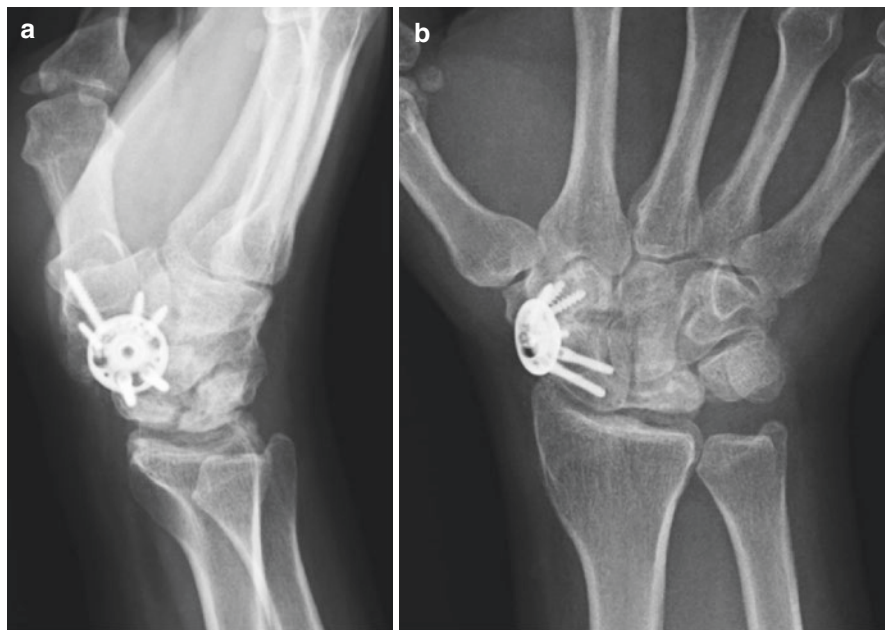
Lateral (a) and anteroposterior (b) wrist radiographs at 18 months after STT fusion using a limited wrist fusion plate limited. From Acar B, et al.: *Cureus* 11(2):e4025, 2019, Fig. 2(a), (b)
